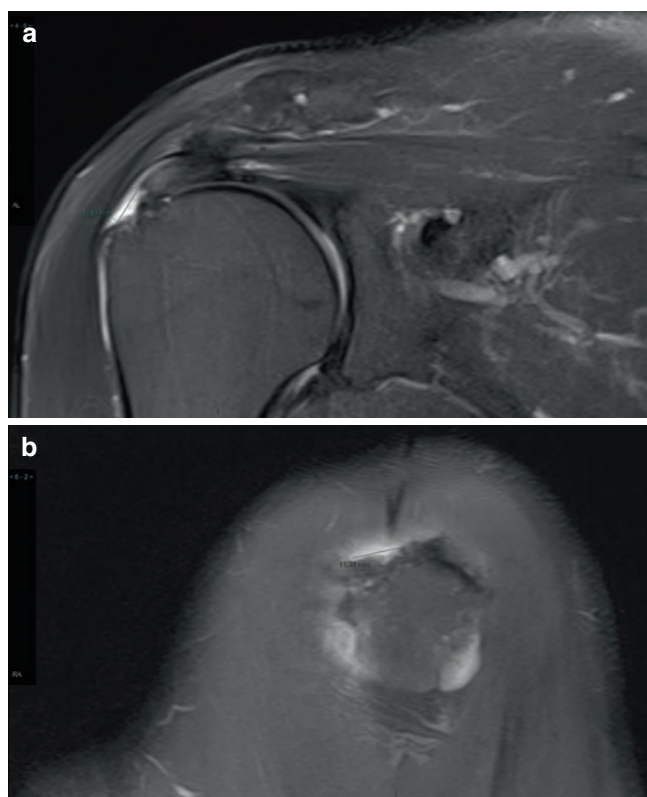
(a) Coronal oblique T2-weighted fat suppressed image showing partial thickness bursal side tear of the supraspinatus tendon, tendinosis and subacromial bursitis. (b) Sagittal T2-weighted image demonstrating the partial thickness bursal side tear, transverse length
